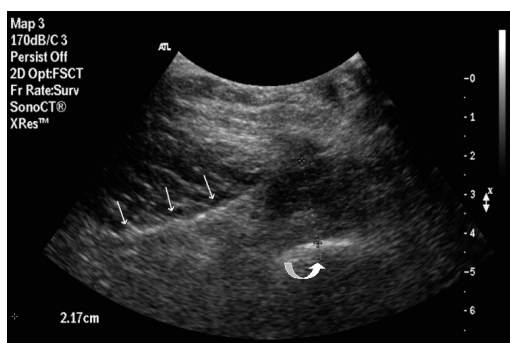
Transversal sonographic appearance of deep fluid collection between fascia lata (arrows) and femoral cortex (curved arrow). Callipers indicate measurement.
